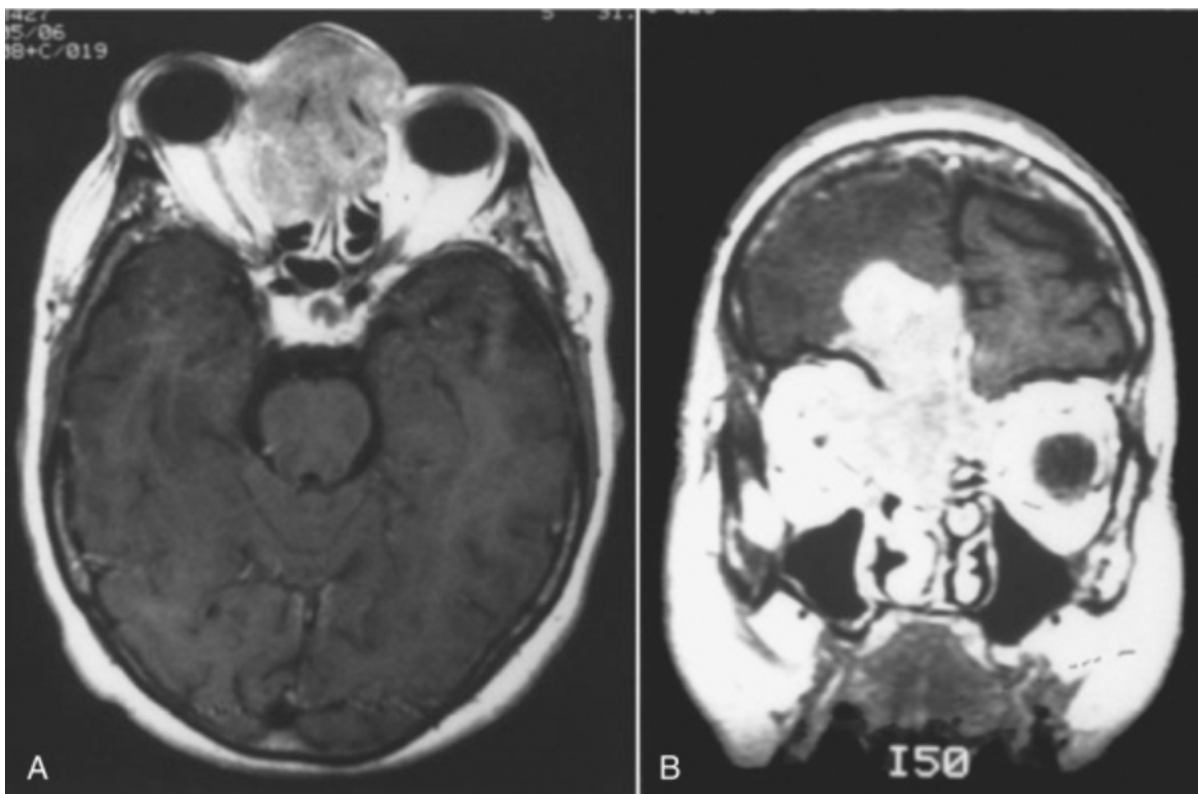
A and B, Magnetic resonance images demonstrating extensive neoplasm with erosion of the skull base and invasion of the right frontal lobe.
